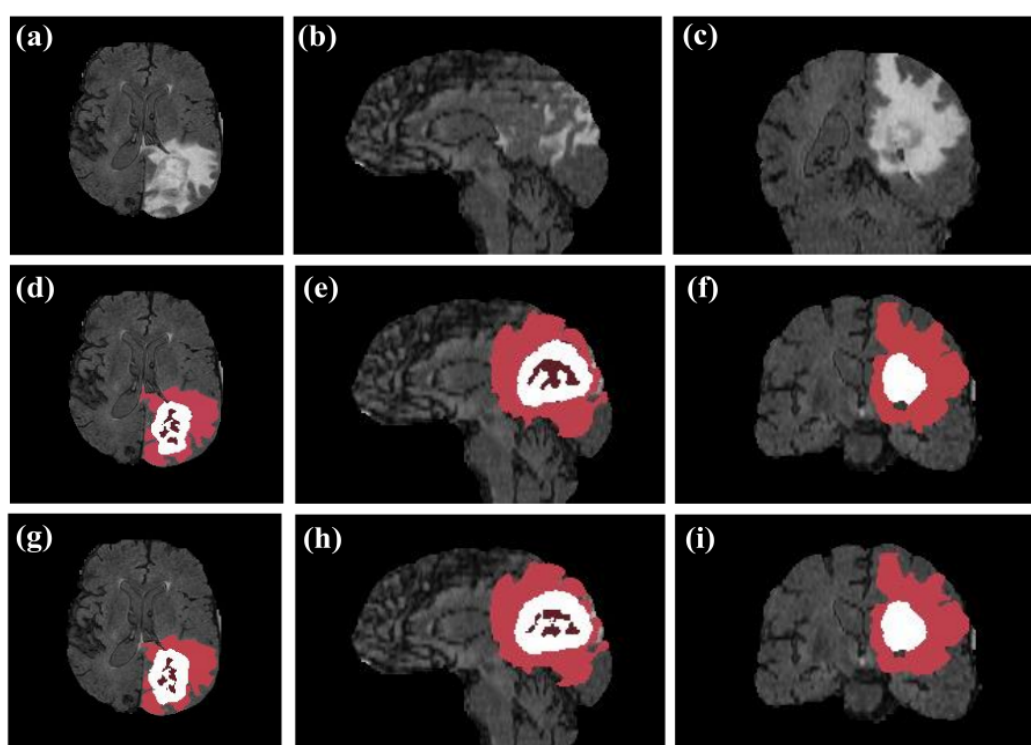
(a), (b), and (c) depict the orthogonal views, namely axial, sagittal, and coronal, of the FLAIR image, respectively. Correspondingly, (d), (e), and (f) represent the corresponding actual segmentation labels. Similarly, (g), (h), and (i) show the corresponding predicted labels. In this representation, the WT is indicated by light-brown, white, and dark-brown colors, the ET lesions are represented by white, and the TC is depicted by a combination of dark brown and white. Upon observation of slices presented in (a), (b), and (c), it is evident that the axial slice contains the most detailed anatomical information. In contrast, the coronal slice provides the least [Rajput et al. (2023b)].
